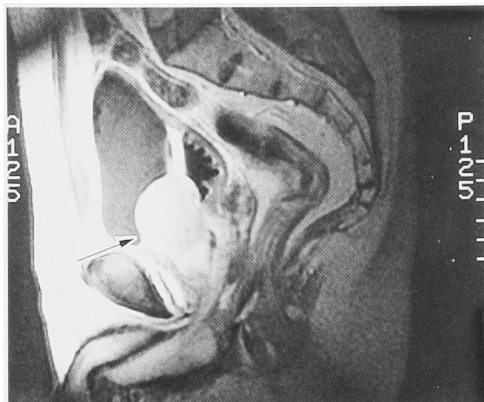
On magnetic resonance imaging of the pelvis, the mass appeared continuous from the bladder neck to the inner portion of the prostate.
